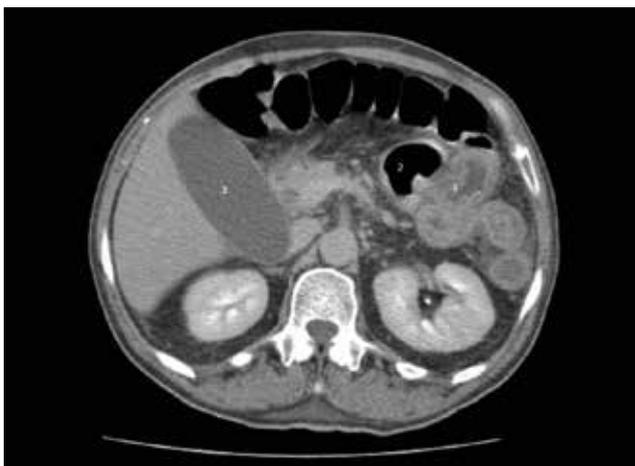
Abdominal computed tomography: 1) Thickened small bowel wall of the ascending duodenum and jejunum; 2) Small bowel dilatation; 3) Large gallbladder
